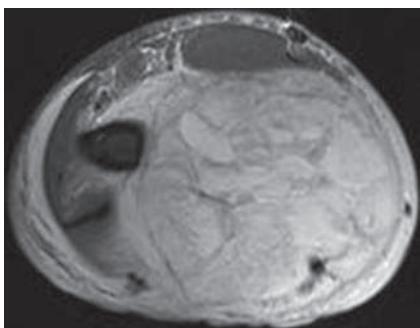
Sarcoma with vascular and neural involvement. Axial T2-weighted fat-saturated MR image shows a high-signal-intensity undifferentiated soft-tissue sarcoma involving the anterior and posterior compartments of the upper arm. The lesion abuts the humeral cortex and involves the brachial vessels and the median and ulnar nerves. Limb salvage could not be performed, and the patient was treated with shoulder disarticulation.
